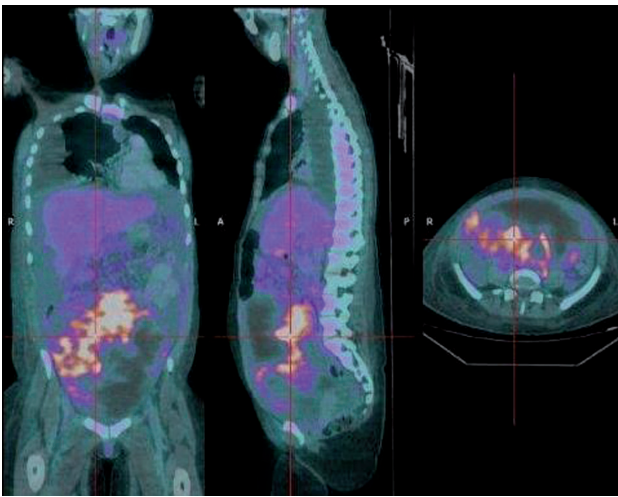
18F-FDG-PET-CT coronal and sagittal images revealing the peritoneal carcinomatosis, ascites, and high volume right-sided pleural effusion. The pleura show no metabolic activity.
